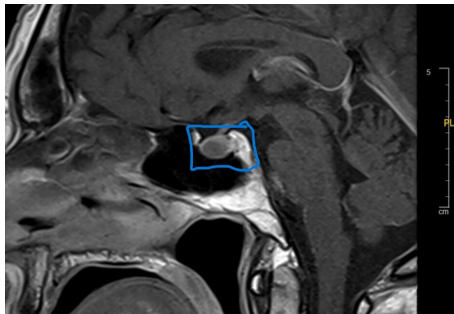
Showing a sagittal section of a contrast MRI pituitary scan in patient demonstrating the Rathke's cleft cyst and displaced pituitary tissue.
